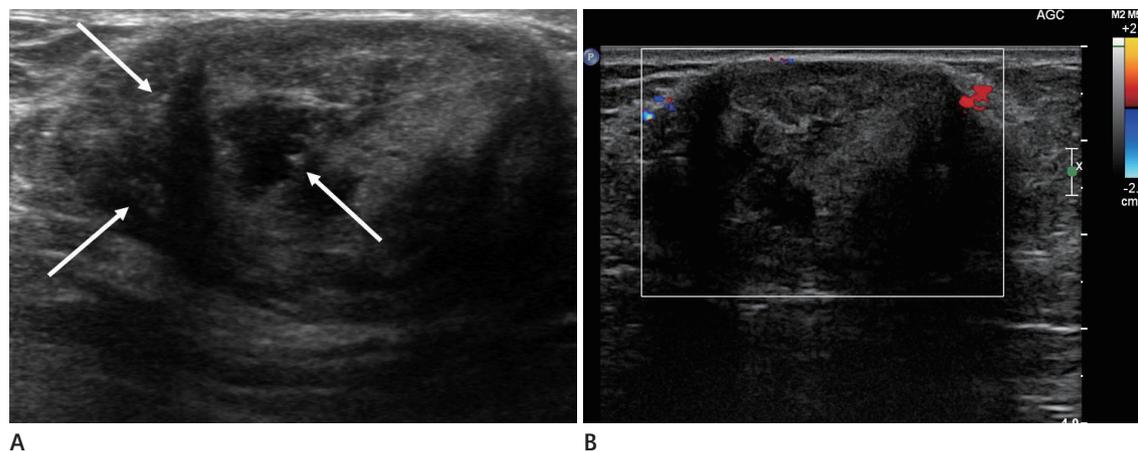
Ultrasonography findings of infarcted hyperplastic breast tissue.
